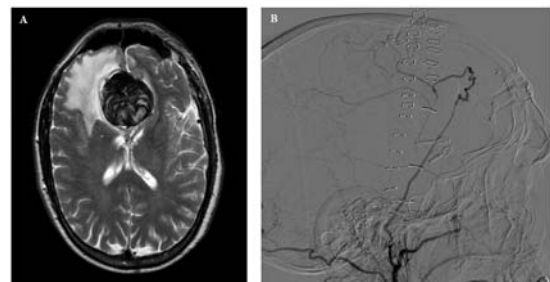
A) Axial T2-weighted MRI demonstrates a mega giant anterior communicating artery aneurysm with intramural hemorrhage and perilesional edema. B) - Postoperative angiogram showing the patency of the bypass from right superficial temporal artery to the A3 segment of the right anterior cerebral artery.
